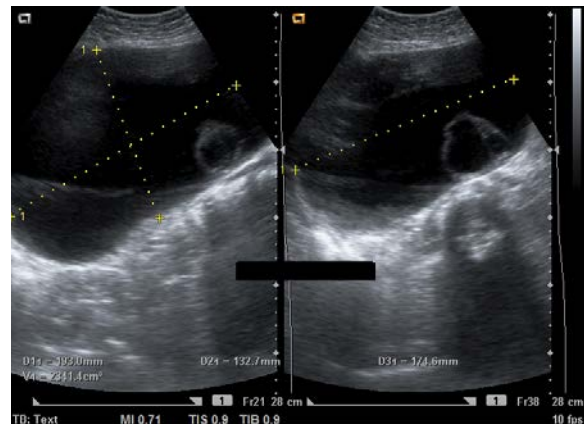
An ultrasound scan of a non-septate ovarian cyst with internal echoes.
